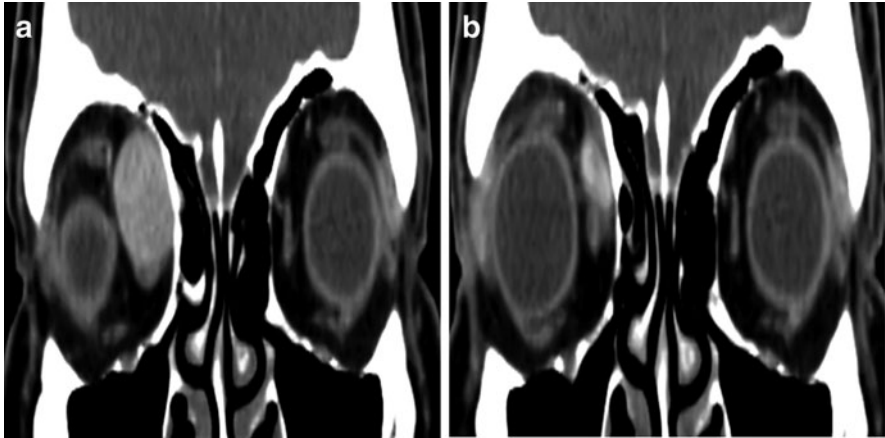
Computed tomography of a recurrent orbital hemangiopericytoma before (a) and after (b) treatment with neoadjuvant radiation therapy which was administered prior to surgical resection of the mass
